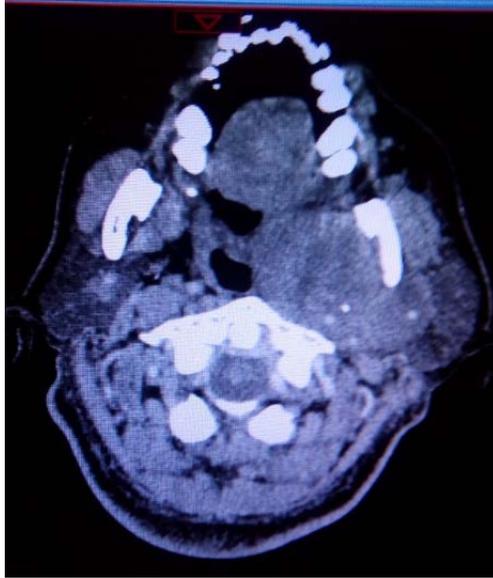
CT scan of the Neck showing heterogeneously enhancing lobulated mass (5.3x6.2x6cm) at the left masticator space with erosion of the left pterygoid plates and encasement of the left internal and external carotid arteries. Subcutaneous fullness at left pre-auricular region with thickening of the walls of the left external auditory canal and erosion of left mastoid cortex. Salivary glands are normal in size and enhancement. No enlarged lymph node seen.
